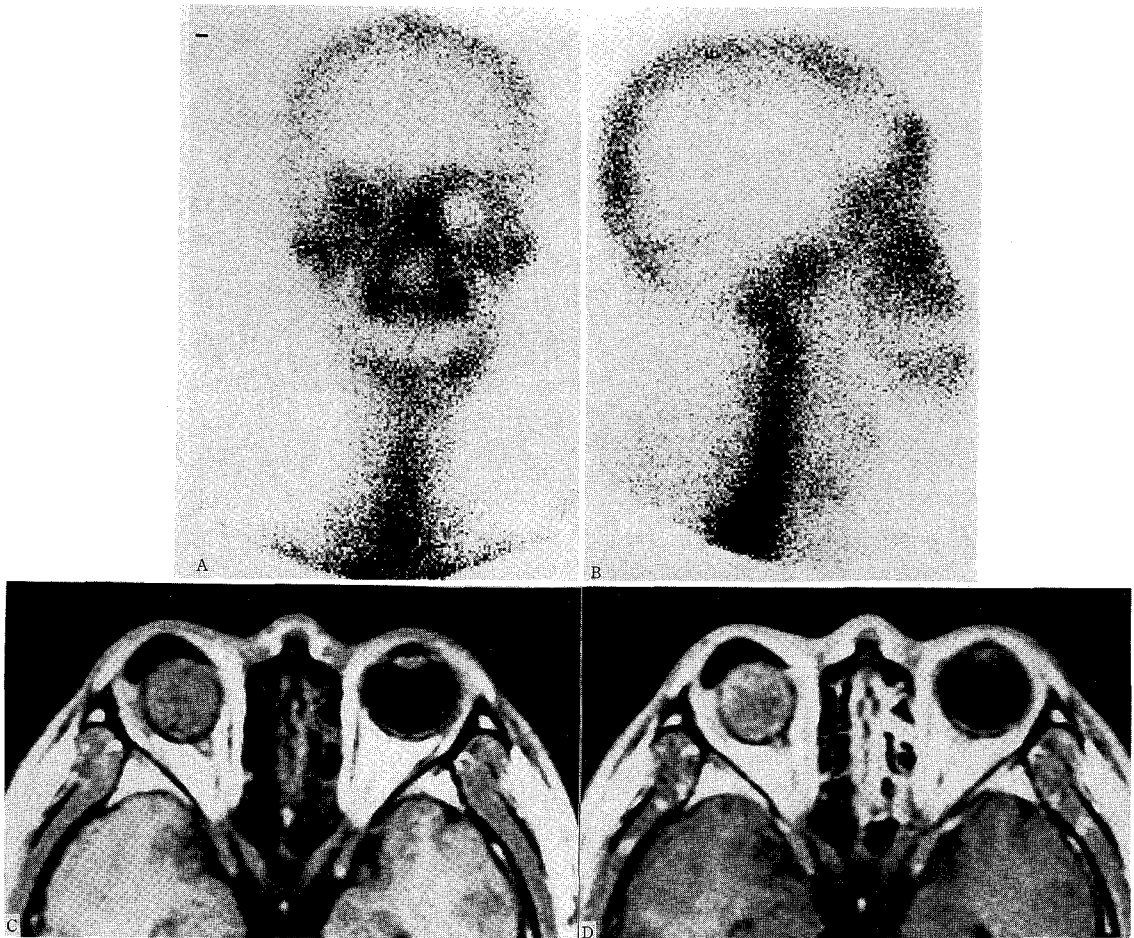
Increased uptake similar to that of nasal bridge is seen in the right orbit on anterior(a) and right lateral(b) ^{99m}Tc -MDP bone scan images of the head of a patient 20 weeks after implantation. Pre-(c) and postcontrast(d) T1-weighted images of the orbit show moderate enhancement in the right ocular implant.
